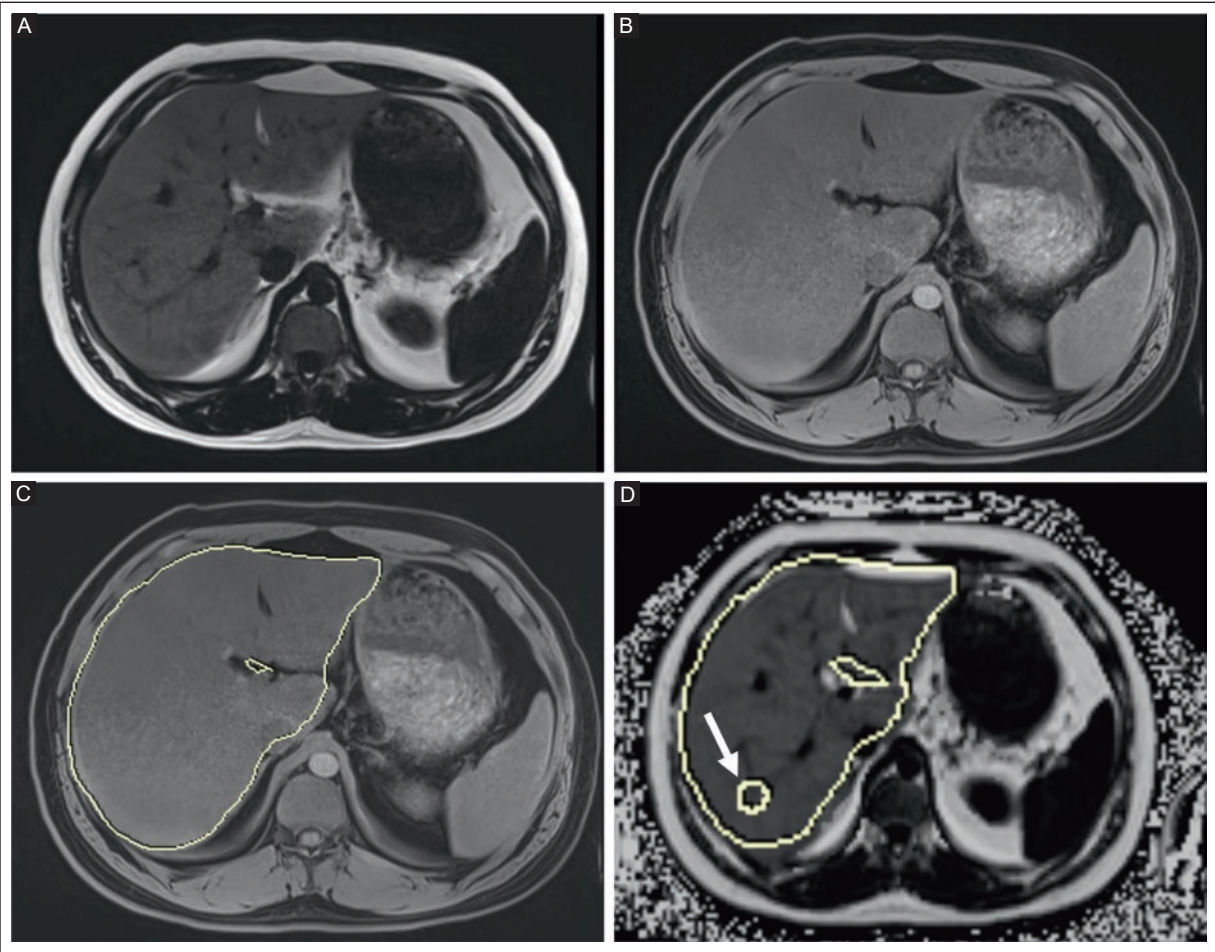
T1 VIBE e-Dixon or First Look Dixon sequence 3D acquisition performed with a single breath-hold with full coverage of the entire hepatic parenchyma, generating the following images: water, fat, and automatic segmentation on water. A: T1 VIBE Dixon Fat shows the macroscopic fat component of tissues without free water protons. This component appear isointense. B: T1 VIBE Dixon Water shows the free water component without the macroscopic fat component; free water protons appear isointense. C: T1 VIBE e-Dixon sequence with automatic MRI-PDFF segmentation performed after acquisition. D: T1 VIBE Dixon Fat Fraction. After acquisition, the system automatically performs liver MRI-PDFF segmentation, and a manual ROI approximately 20 mm in size is placed over the hepatic parenchyma, standardized to hepatic segment VII (arrow).
